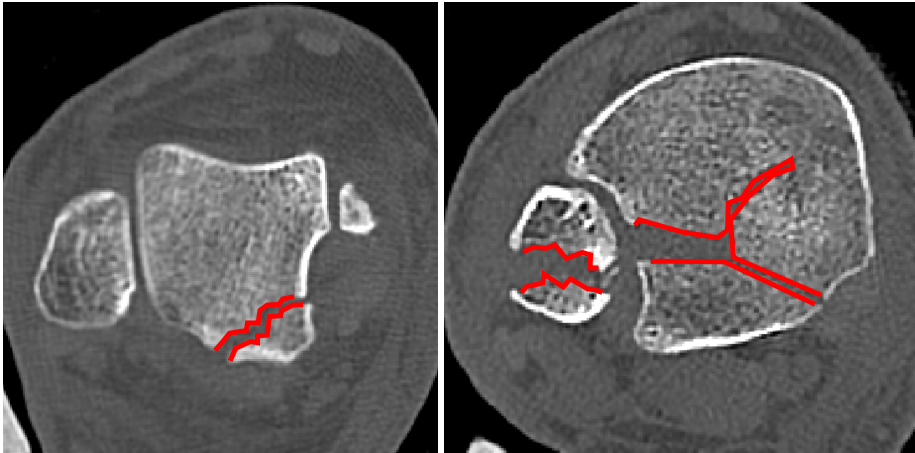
CT slices that represent some different simple bone fractures. Fracture lines are marked by hand in red.
